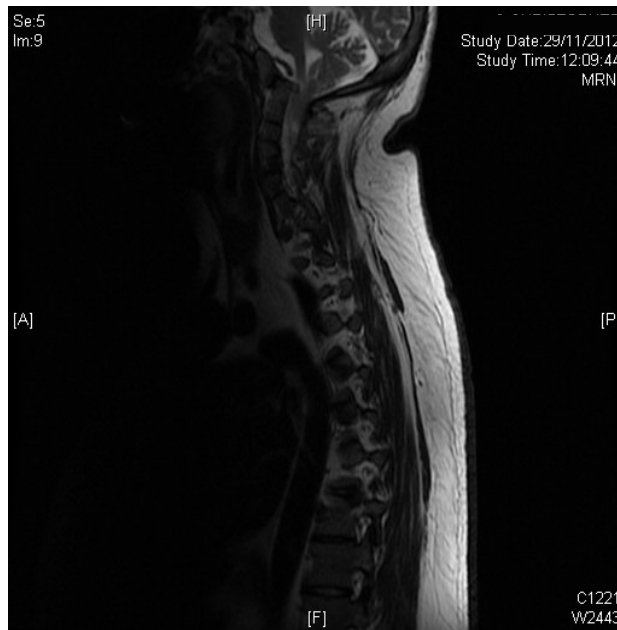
MRI scan showing the cerebellar herniation through the foramen magnum and vertebral fusion.
